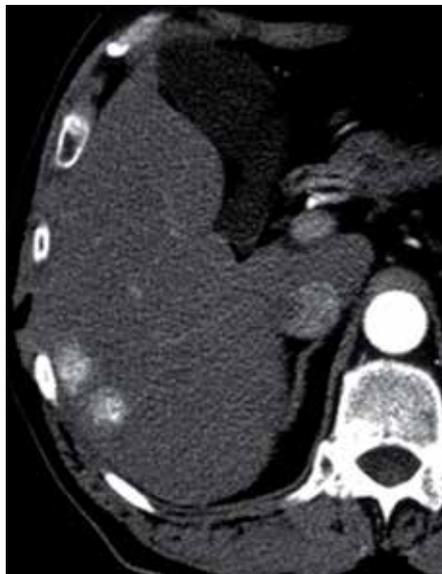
Computed tomography of hypervascular liver metastases from a renal primary tumor at the arterial phase.
